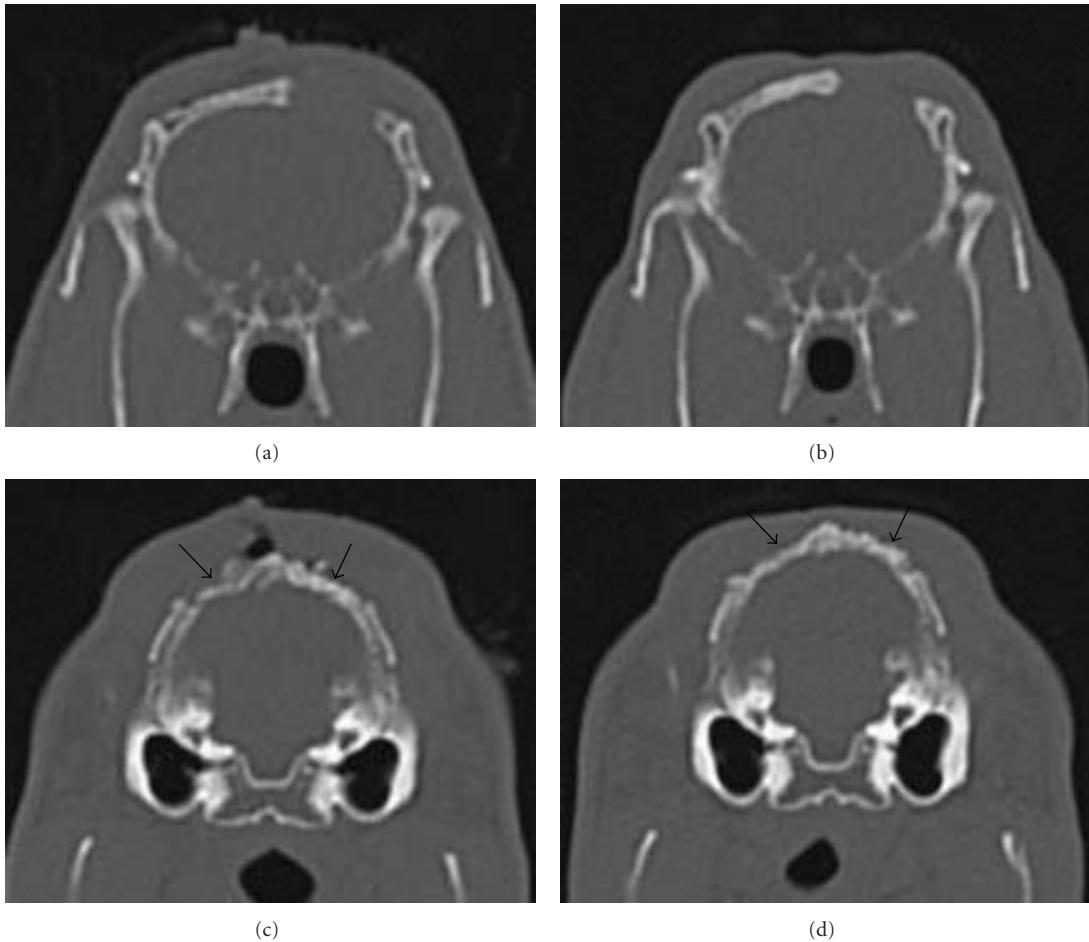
Post-op CT scan of (a) unfilled area immediately after surgery; (b) unfilled area 6 weeks postoperatively; (c) dentin-filled defect (right arrow) and the autogenous bone-filled defect (left arrow) immediately after surgery; (d) dentin-filled defect (right arrow) and the autogenous bone-filled defect (left arrow) 6 weeks postoperatively.
